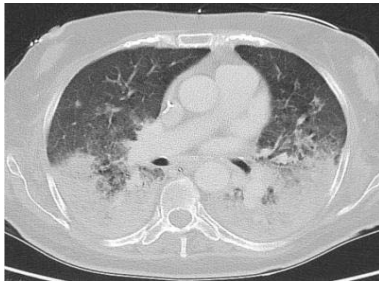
Contrast-enhanced thorax CT scan demonstrates diffuse bilateral infiltrates involving >50% of lung parenchyma with dorsal consolidation areas.
